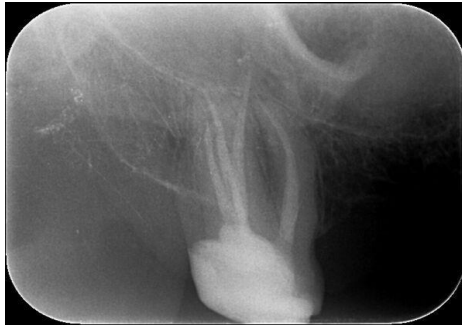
Six-month radiograph
